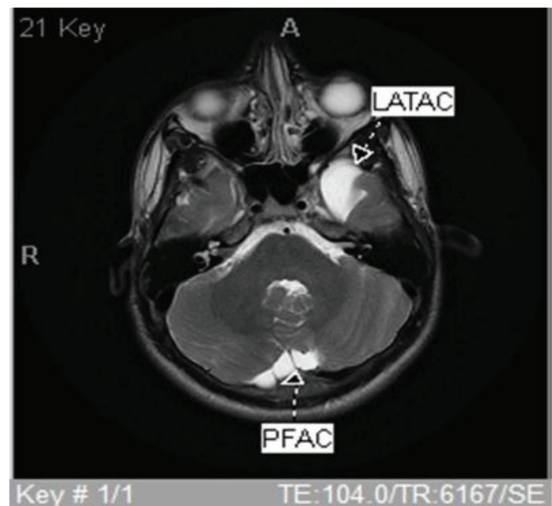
T2-weighted axial MRI showing left anterior temporal arachnoid cyst (LATAAC) and PFAC
